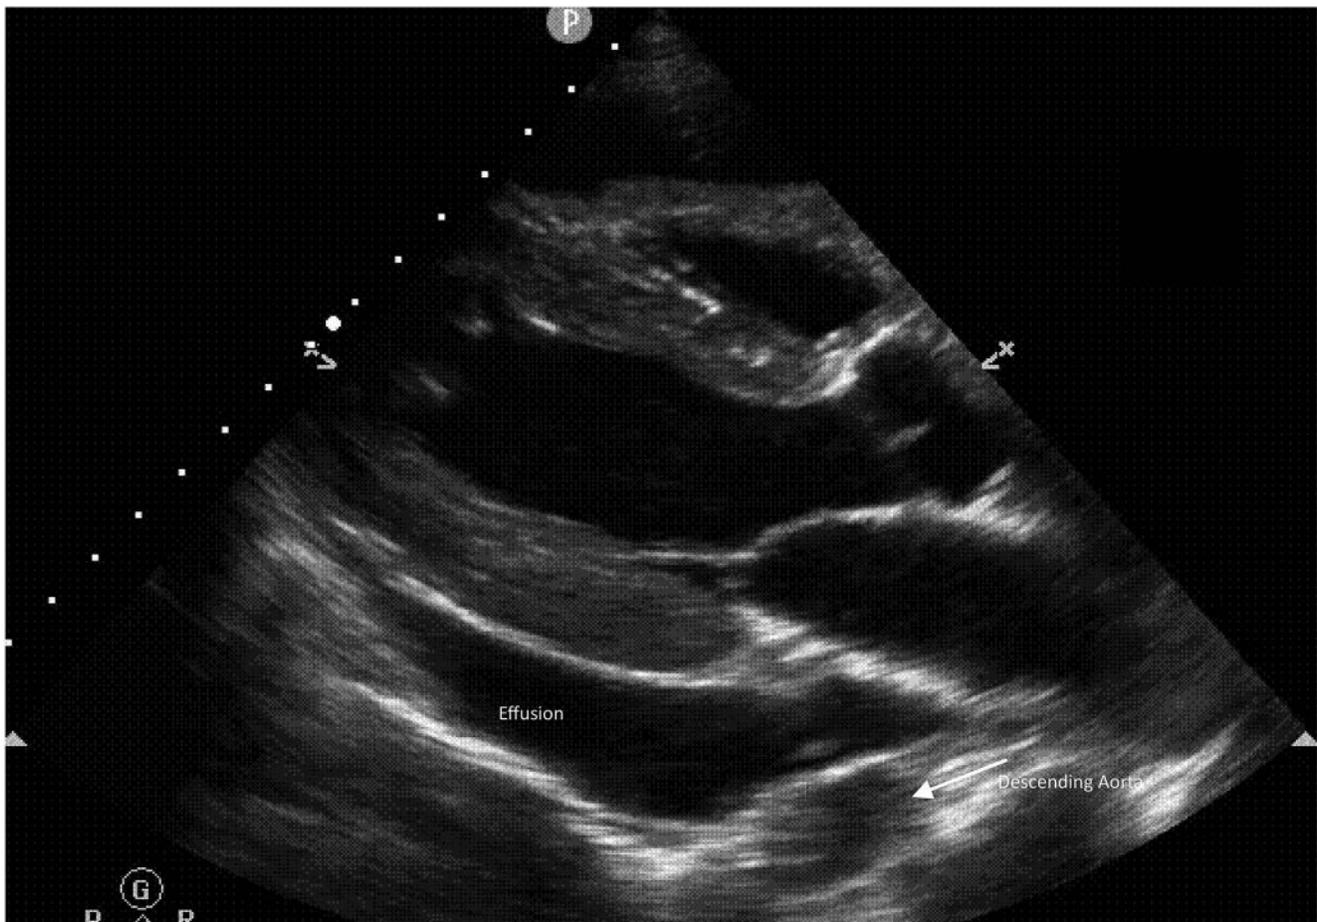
Parasternal long-axis (PLAX) with pericardial effusion and right ventricular (RV) diastolic collapse.⁴
